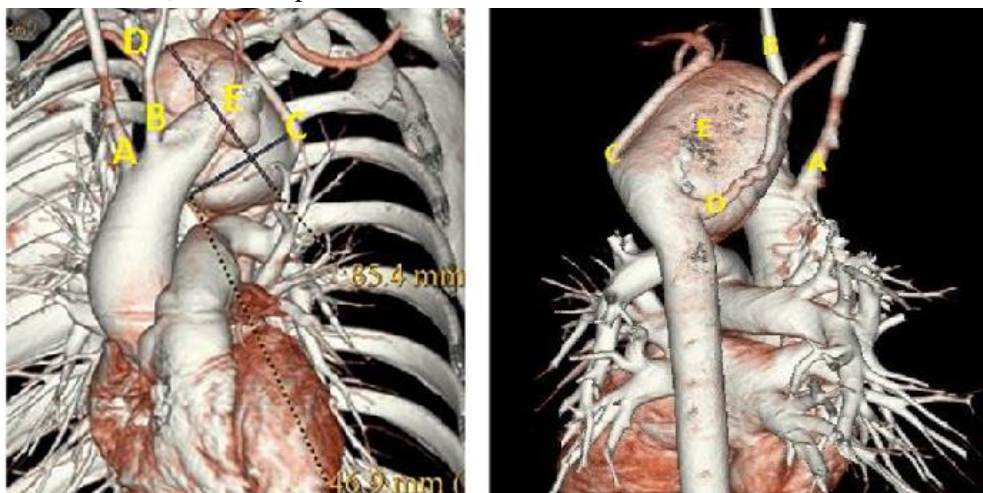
3-D reconstructed CT showing antero-posterior and posterior-anterior views respectively, a huge saccular aneurysm of the proximal descending thoracic aorta (KD with ARSA from a left-sided aortic arch.), A- right common carotid artery; B-left common carotid artery; C-left subclavian artery; D- the aberrant right subclavian artery; E-micro-aneurysm on the KD.
